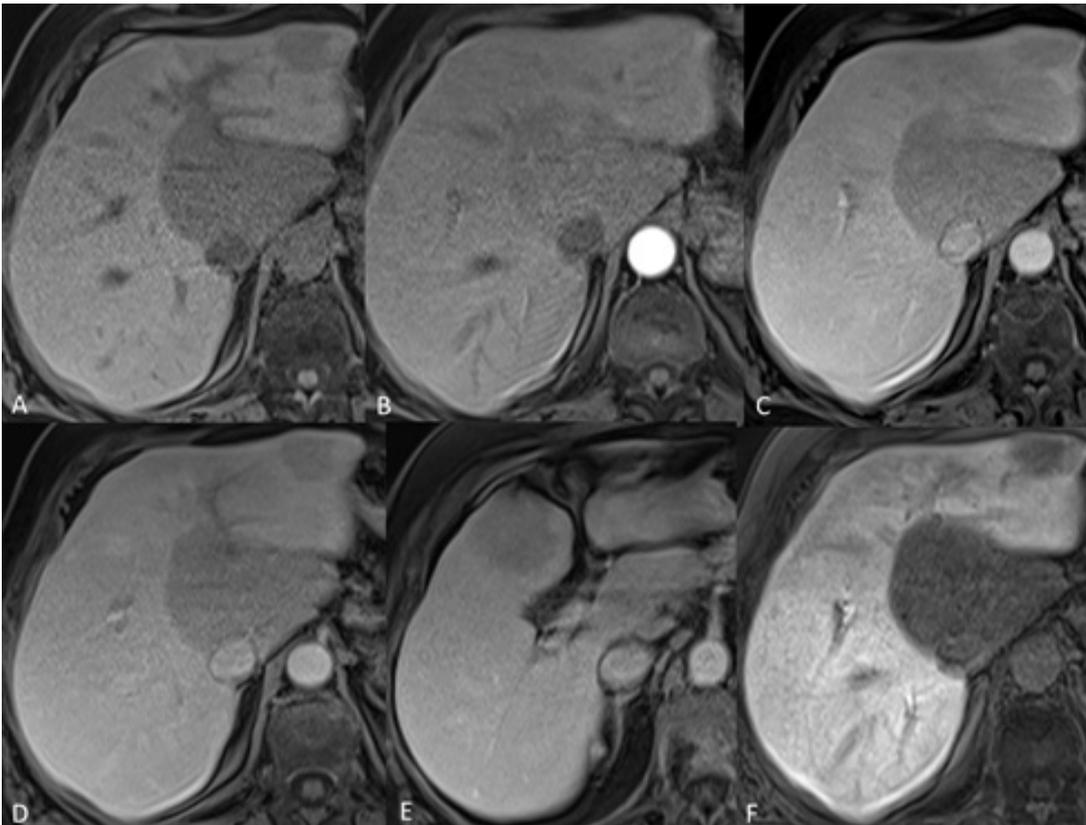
Contrast-enhanced MRI using Gd-EOB-DTPA (pre-contrast; arterial phase; portal venous phase; transitional phase; hepatobiliary phase). All lesions remain hypointense for the entire study, including the hepatobiliary phase.
